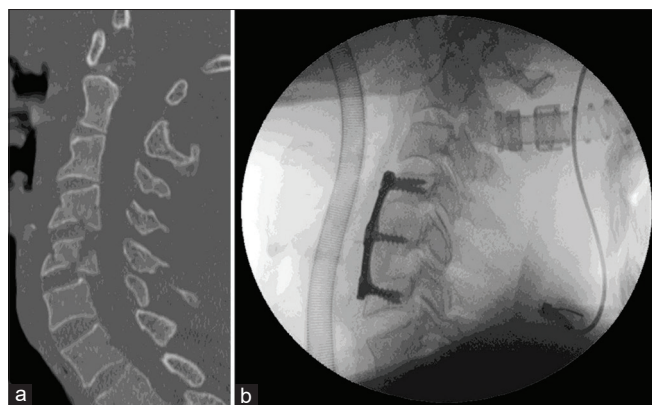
(a) Cervical fracture-dislocation. Admission computed tomography scan, May 2011: sagittal views. "Fracture-dislocation of the C4 vertebra on the C5 vertebra and C5 vertebra on the C6 vertebra with retrolisthesis. Associated laminar fractures and subdislocation of the facet joints of C4-C5 and C5-C6 (b) Cervical fracture-dislocation. Fluoroscopic intraoperative lateral view: C5 corpectomy with anterior cervical fusion with iliac crest autograft (Badgley and Bailey) and C4-C6 plate.
